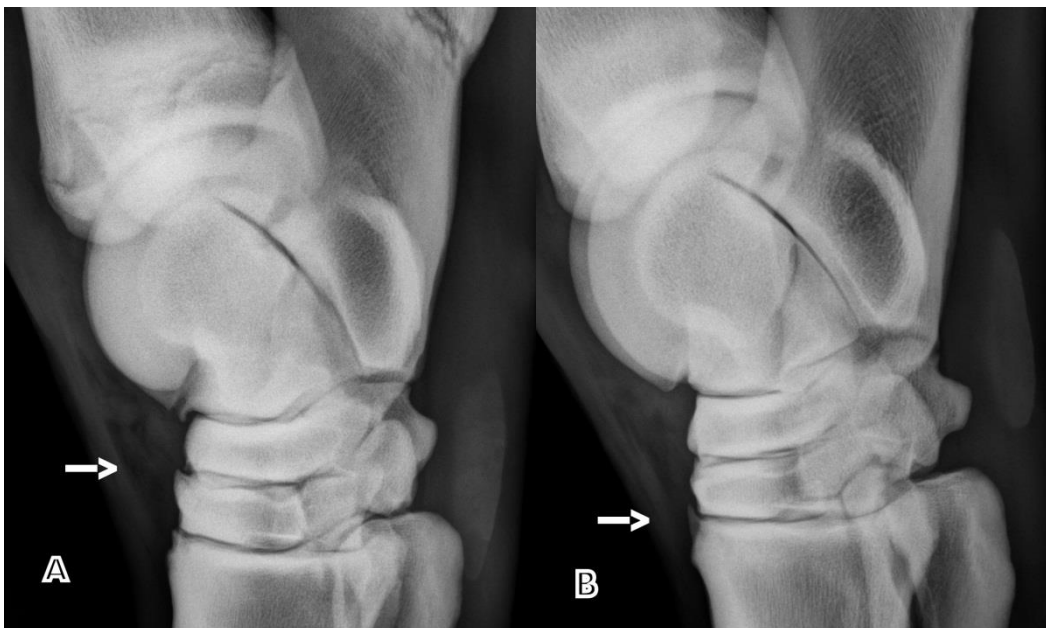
Lateromedial radiographic view of tarsus showing osteophytes or enthesophytes (arrows) at the (A) centrodistal (distal intertarsal) and (B) tarsometatarsal joint margins.
